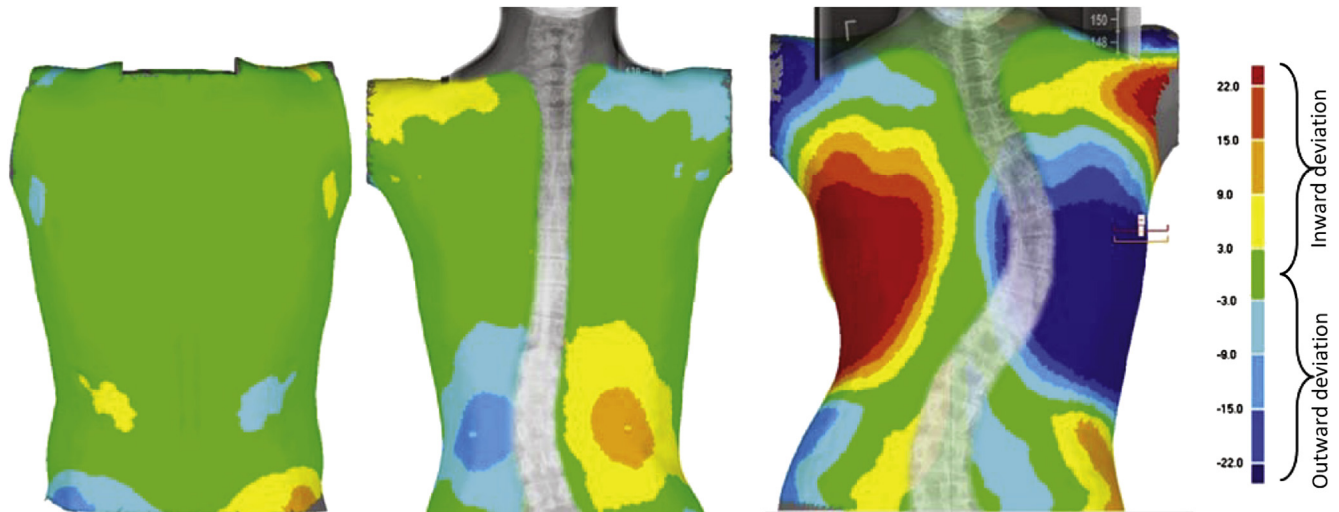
The surface topography color asymmetry deviation map of subjects with (Left) normal spine, (Middle) mild scoliosis, and (Right) severe scoliosis with their corresponding radiograph. To minimize radiation exposure, the radiograph of the healthy subject was not available.
